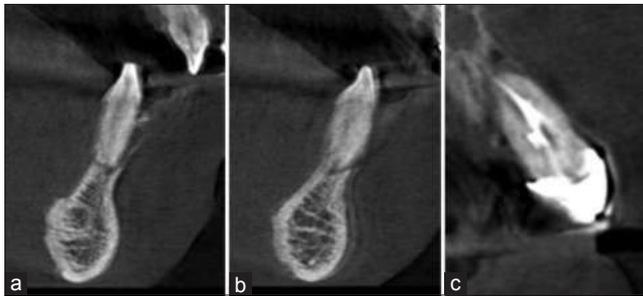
(a-c) Cross-sectional cone-beam computed tomography images of tooth number 31, 41, and 21, respectively, showing vertical fracture lines
